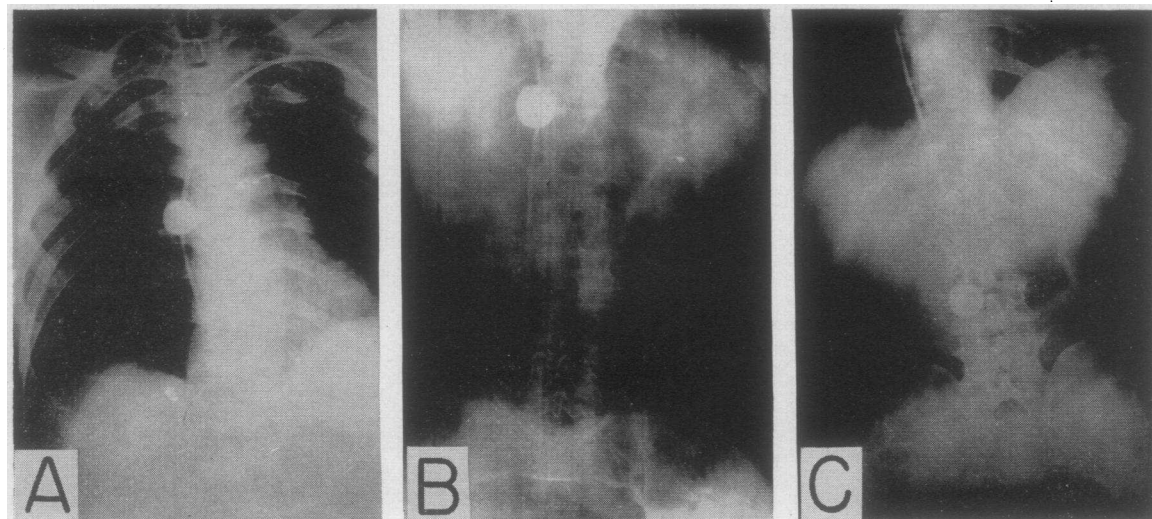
X-RAYS SHOWING IDENTIFICATION AND POSITIONING OF THE INFLATED BALLOON
